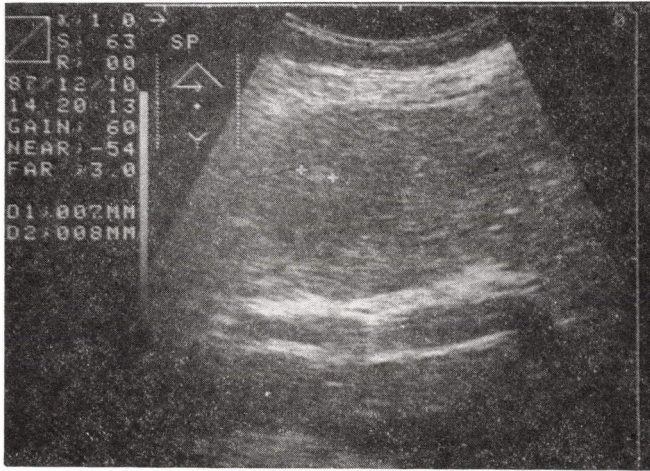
Ultrasonogram of liver metastasis
